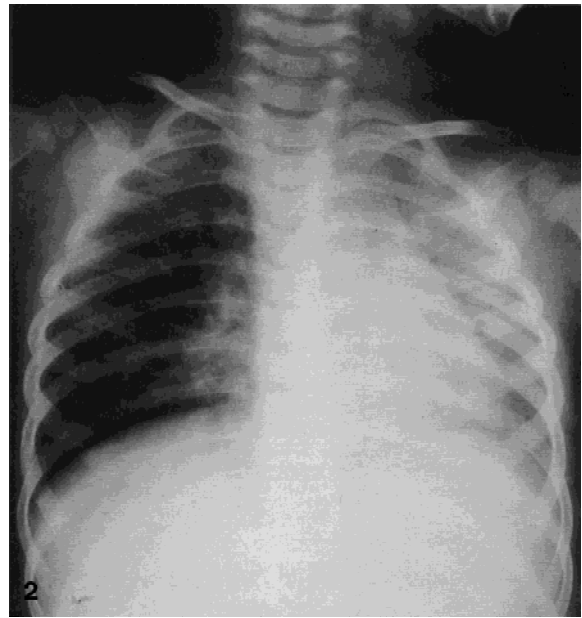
Chest x-ray in 1-year-old girl showing mediastinal shift to the left, air trapping to the right, extended intercostal spaces on the right, and compressed lung on the left. The cause was an aspirated piece of a pumpkin seed in the right main bronchus.
